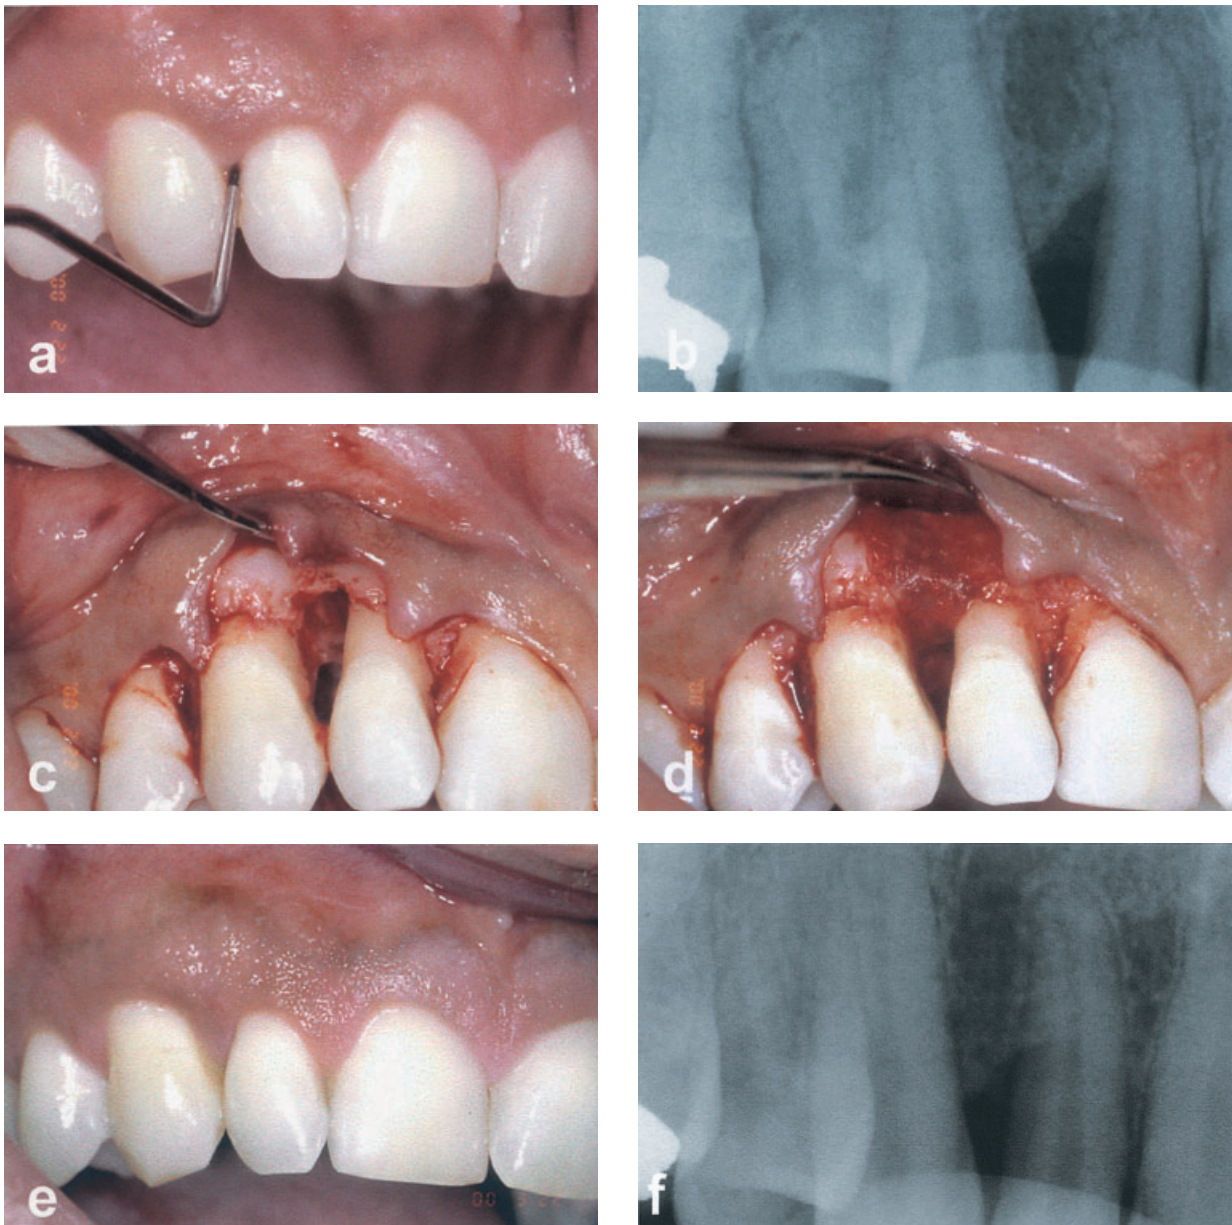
Right lateral maxillary incisor with an 8-mm deep pocket associated with an intrabony defect on the distal aspect (a), as seen on the radiograph (b). Full-thickness buccal and palatal flaps have been raised and the defect has been debrided (c). A bioabsorbable membrane has been adopted over the defect (d). The level of the interdental gingiva is maintained after 1 year (e) and the intrabony defect (f) is resolved.
